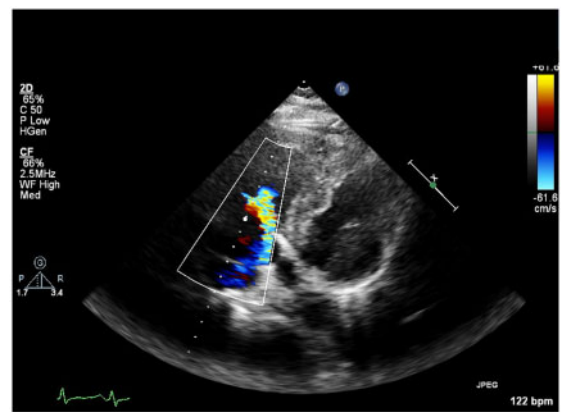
Bedside echocardiogram with subcostal view and colour Doppler of the tricuspid valve showing at least moderate tricuspid regurgitation.
